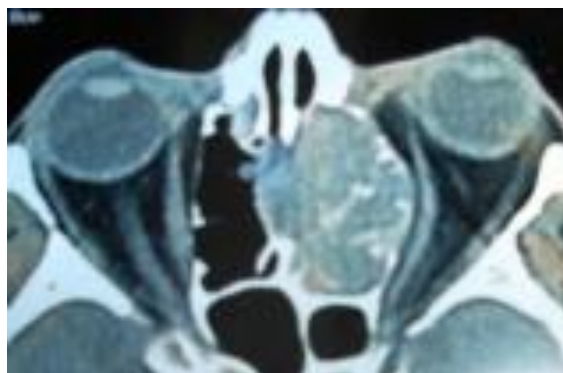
CT scan axial cut, showing the extent of the tumor
